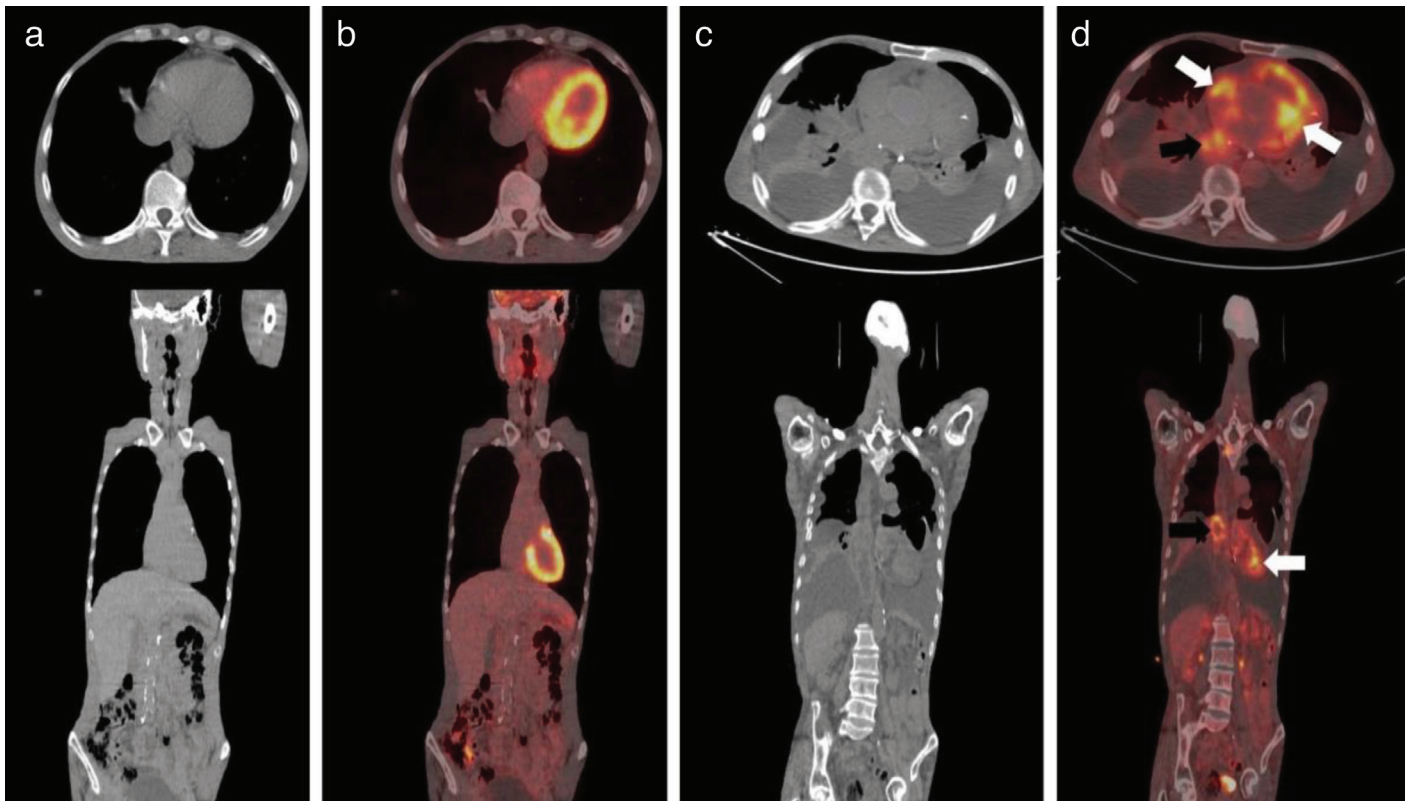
(a) Normal CT images prior to cancer recurrence. (b) Normal myocardial FDG-18 uptake in PET/CT. (c) CT imaging showing myocardial thickening with a heterogeneous appearance secondary to cancer invasion after recurrence. (d) PET/CT revealing pathological FDG-18 uptake in the lower esophagus (black arrow) and myocardium (white arrow) indicative of malignancy involvement.
